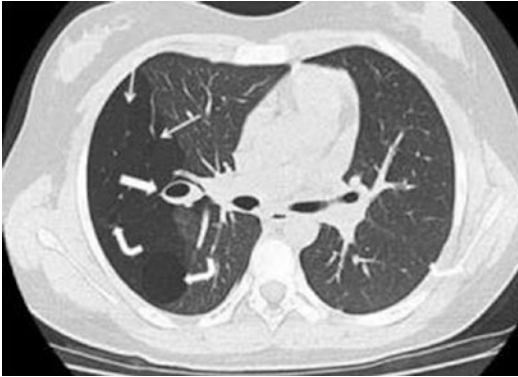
Bronchial atresia in a 12-year-old girl with a history of recent right pneumonia. A CT scan of the chest below the carina shows a zone of greater transparency in the right lung (*thin arrows*), associated with mucosal impaction and a mucocele in the hilar region on the same side (*thick arrow*). There are also two thin-walled cystic masses inside, compatible with a congenital pulmonary airway malformation (formerly known as a congenital cystic adenomatoid malformation) (*curved arrows*)
